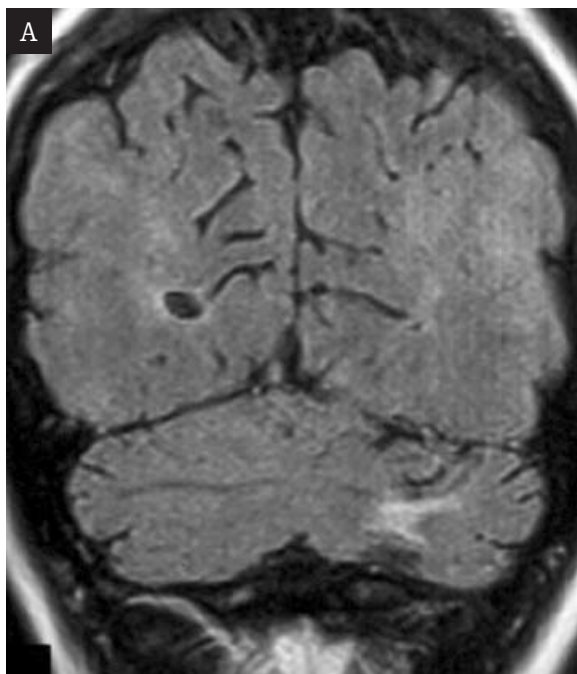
Cerebellar tubers. Coronal FLAIR and T1WI pre- and after contrast injection. A – Coronal FLAIR sequence shows cerebellar tuber with atrophy. B – Transverse T1-weighted image shows hypointense signal of two cerebellar tubers. Image after gadolinium injection – only one cerebellar tuber shows contrast enhancement.
